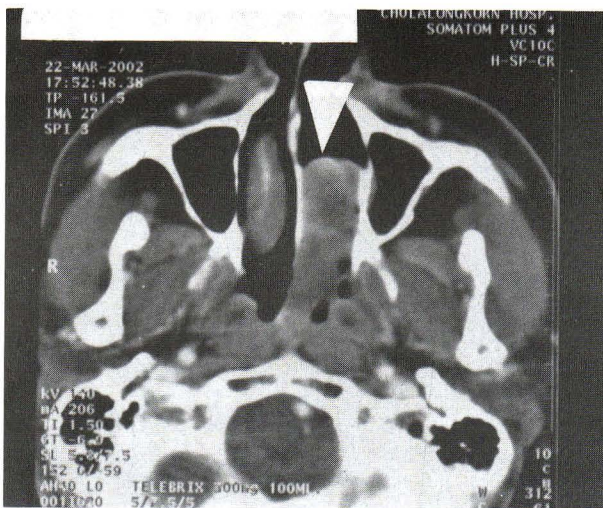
Axial CT scan post contrast study at the level of nasopharynx shows enhancing soft tissue mass (arrow) occupying the posterior part of left nasal cavity.
